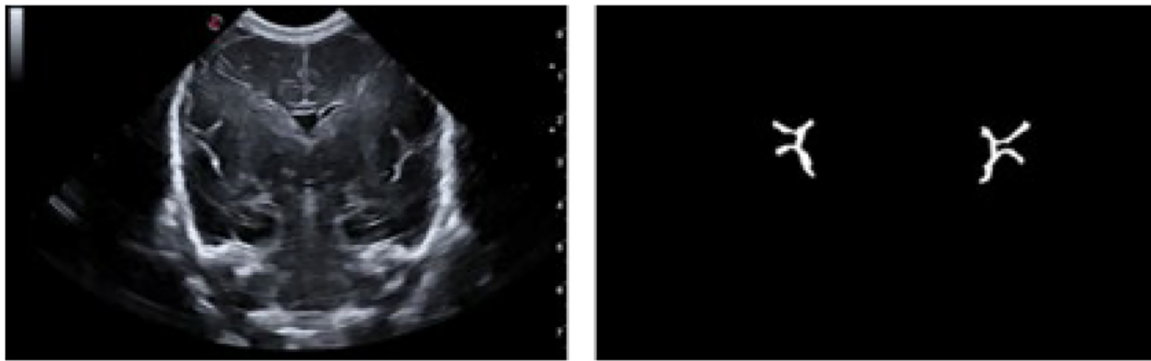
Example of the ultrasound image (left) and its corresponding binary mask of Sylvian sulcus segmentation (right).
